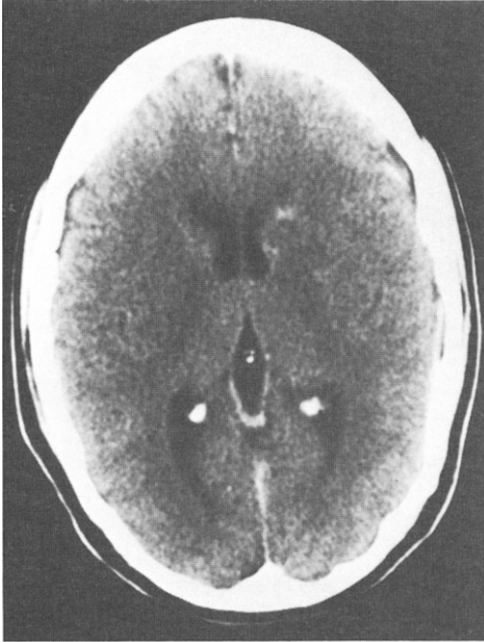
CT scan obtained at the time of the patient's initial presentation. Note contrast-enhanced lucency in the region of the left caudate nucleus with impingement into the left lateral ventricle.
